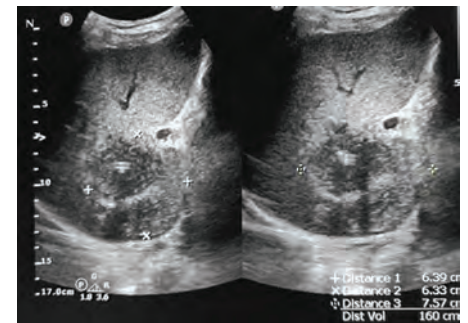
Ultrasound showing residual liver abscess of size 160 cc with pigtail *in situ*
